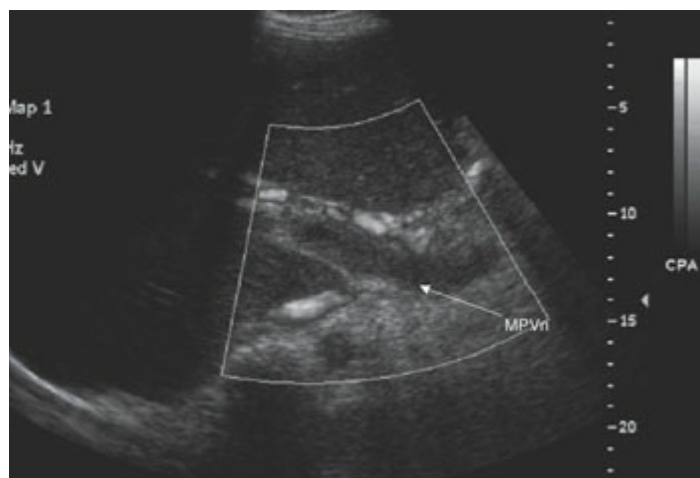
Sagittal, color Doppler image of the main portal vein (*MPVn*) reveals portal vein thrombosis and the development of collateral vessels diverting blood
